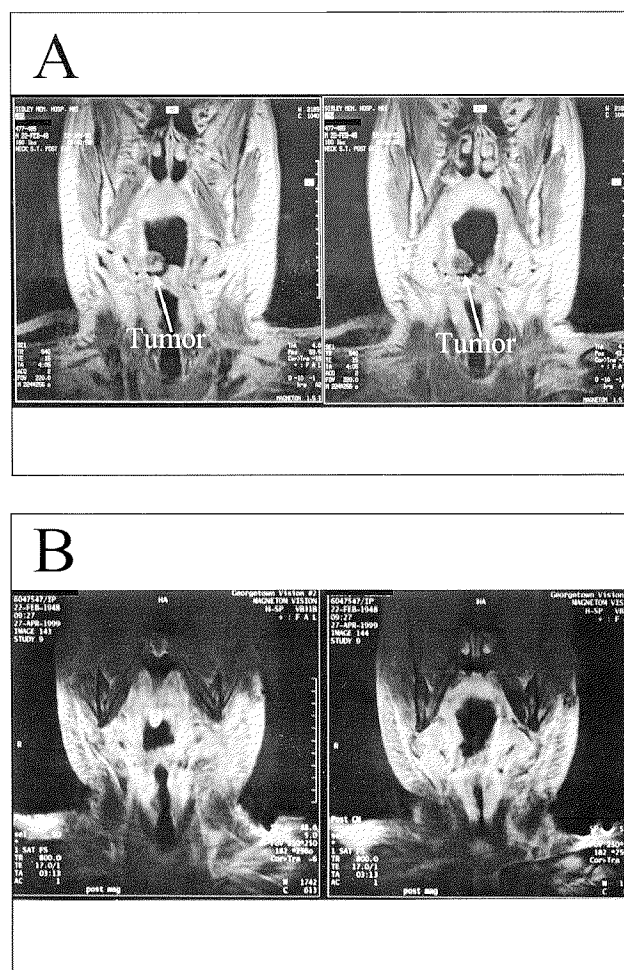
Complete response in a man with tonsillar carcinoma. (A) Baseline MRI image showing a 1.5-cm tumor at the junction of the right tongue base and tonsillar pillar. (B) MRI image at month 3 showing complete resolution of tumor.
